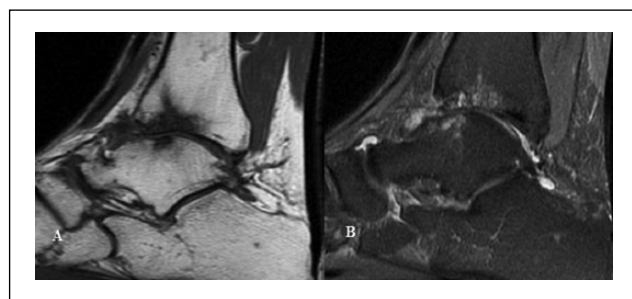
MRI T1-sagittal (A) and STIR (B) scans of patient 2 after 2 years from surgery: the images show a complete filling of the talar defect. The tibial defect is only partially filled.
